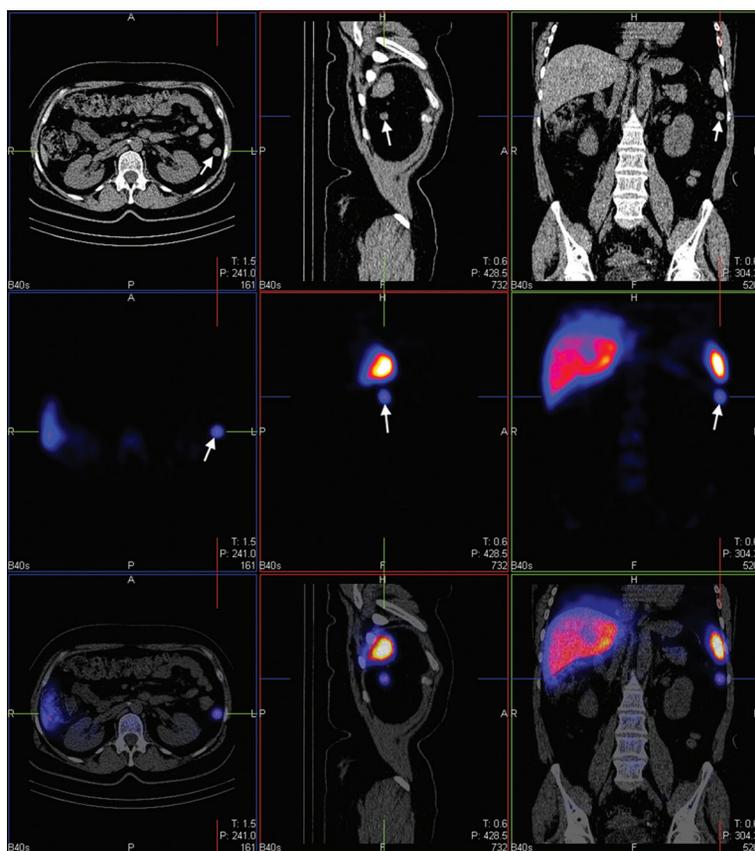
Patient 1. Radionuclide study: computed tomography (CT), pure single photon emission computed tomography (SPECT) and SPECT/CT scans. Axial, sagittal and coronal scans. Accessory spleen located below the "main" spleen (arrow). Also note slight radiotracer uptake in bone marrow of vertebrae.
